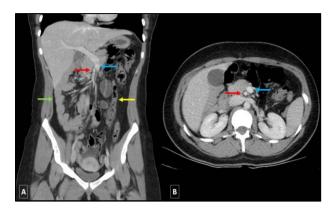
(A and B) CT scan showing the small bowel predominantly located on the right (green arrow) and the colon on the left of the peritoneal cavity (yellow arrow); Inversion of the relationship between SMA (red arrow) and SMV (blue arrow); coronal plane; and transverse plane.
